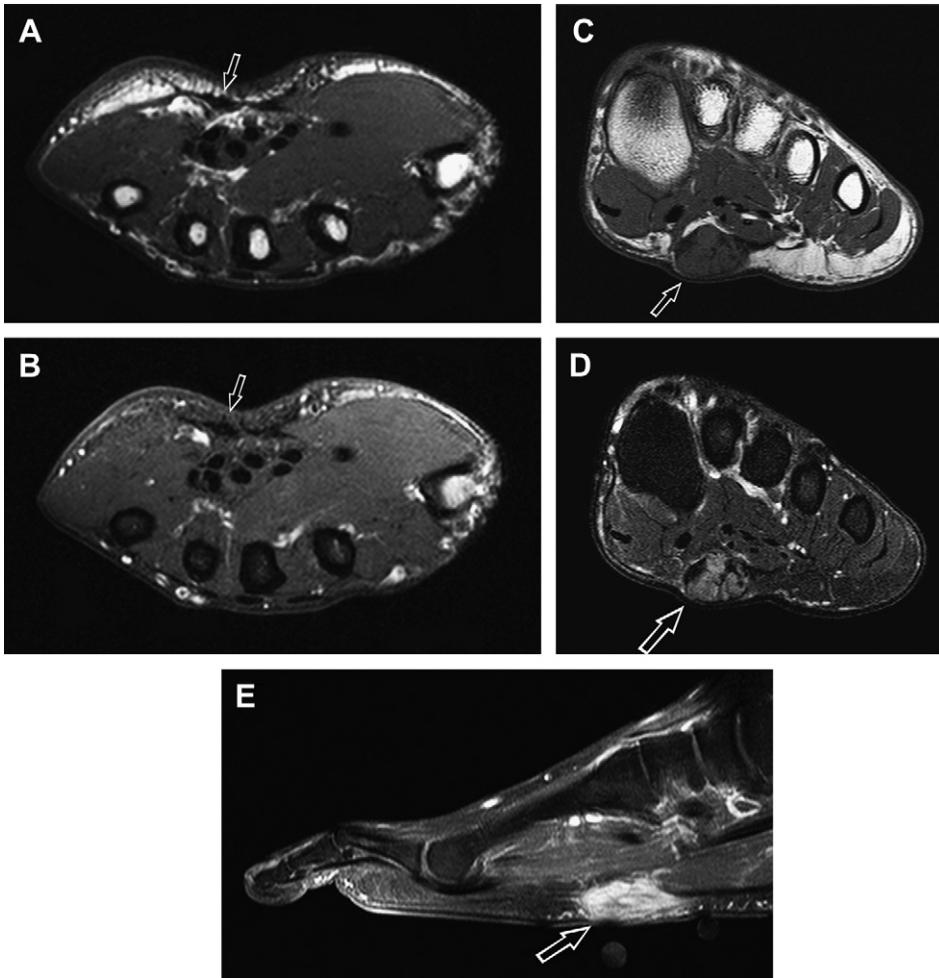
Superficial fibromatosis. Palmar fibromatosis in a 44-year-old man with palmar pain at the midhypothenar eminence (A, B). (A) Axial T1W and (B) axial fat-suppressed T1W postcontrast (TR/echo time [TR/TE], 500/21) images reveal low-signal nodular thickening of the palmar fascia (arrows). (C–E) Plantar fibromatosis in a 54-year-old man with left foot pain for 1 year. MR images demonstrate a well-defined mass (arrows) in the medial aspect of the plantar aponeurosis (C). Short-axis T1W (TR/TE, 568.5/15) sequence reveals the mass with lesion signal intensity similar to skeletal muscle. There is heterogeneity with several foci of low signal within the lesion. The signal intensity of the mass is intermediate to hyperintense relative to skeletal muscle and heterogeneous on (D) short-axis T2W image with fat saturation (TR/TE, 2693.7/60), and there is marked heterogeneous enhancement on (E) sagittal fat-suppressed T1W postcontrast (TR/TE, 539.5/15) image with linear extension along the plantar aponeurosis.
